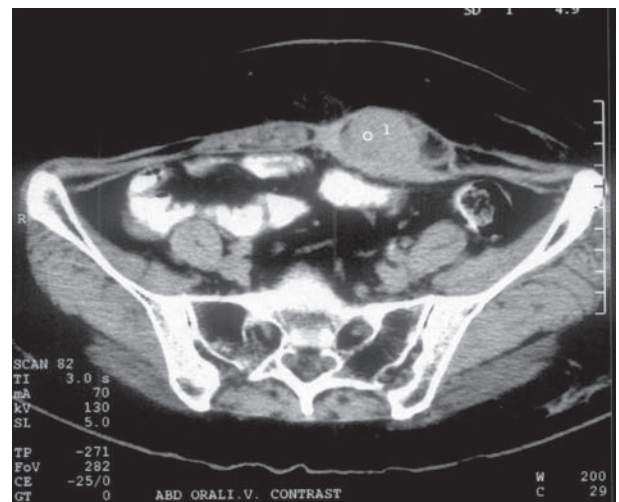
CT Scan showing dense soft tissue mass in the subcutaneous planes involving the left rectal muscle.
